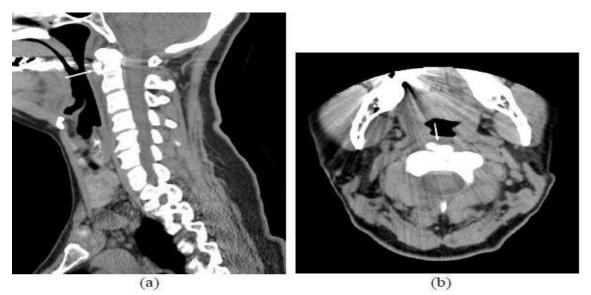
Initial Neck CT. a. sagittal view. b transverse view. Both of them reveal high density calcification deposition (arrow) at just inferior of atlas tubercle.
